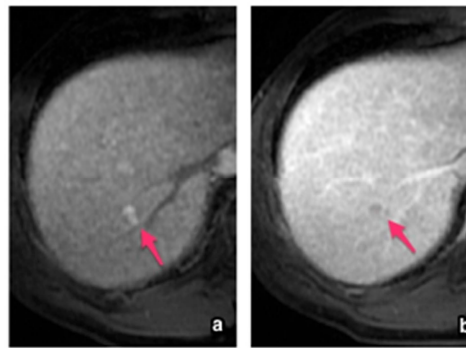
A 50-year-old male with a small HCC in S7 (arrow) showed on unenhanced combined enhanced MR imaging (a: arterial phase, b: delayed phase). Both of the 2 readers categorized this lesion as an arterial phase hyper-enhanced lesion. While one reader categorized the peripheral delayed enhancement as part of the septated solid mass, and the other reader categorized it as capsule appearance. Thus, according to LI-RADS 2014, the 2 readers categorized this lesion as LR4 and LR 5.
